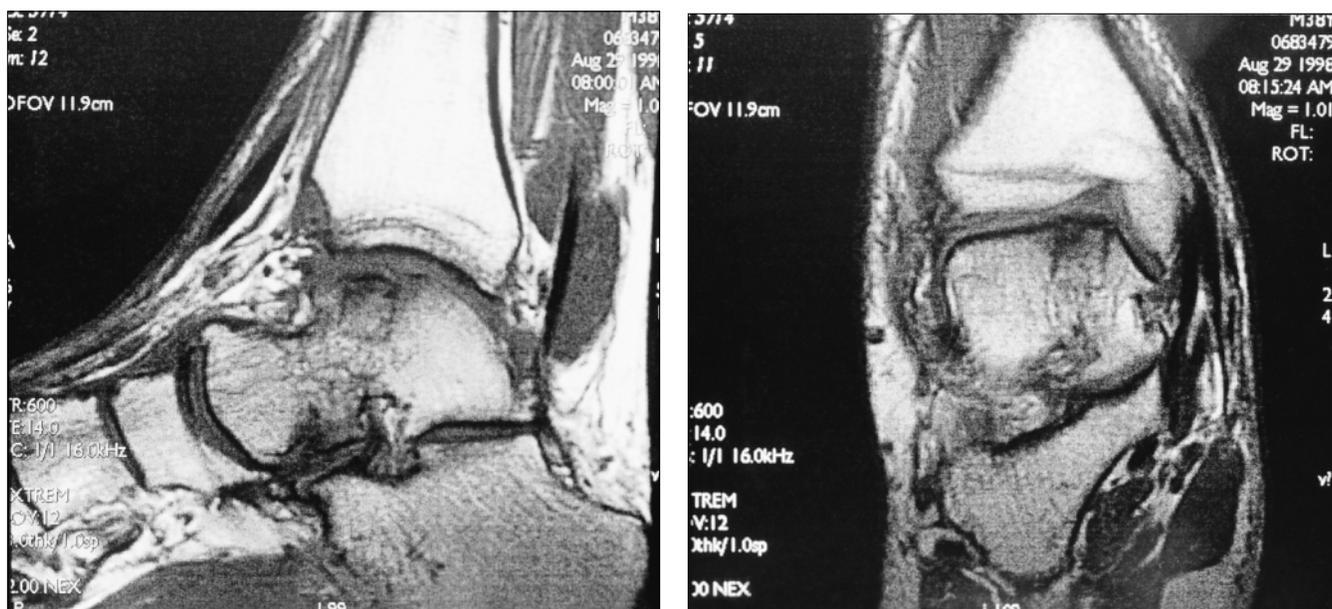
MRI demonstrates a mild articular irregularity (approximately 2 mm) of the talar dome but no significant bone marrow edema.
